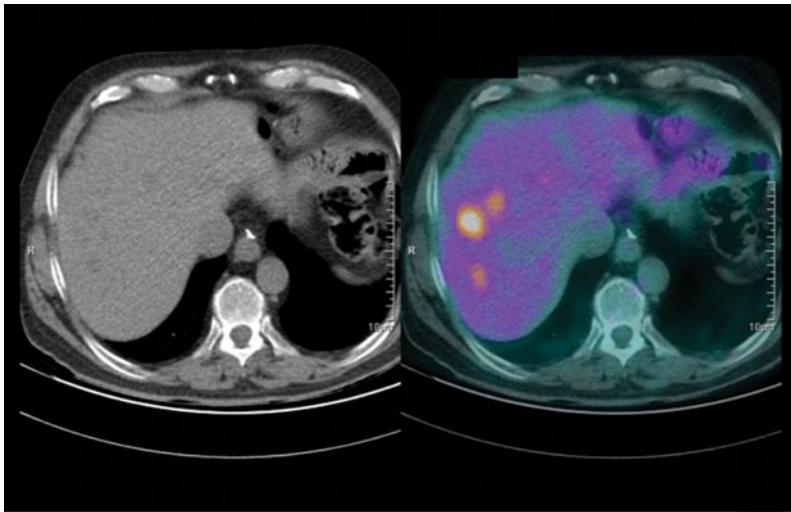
^{18}F -FDG PET/CT scan showing three liver metastases 12 months after subtotal gastrectomy for locally advanced gastric cancer (pT3N0)
